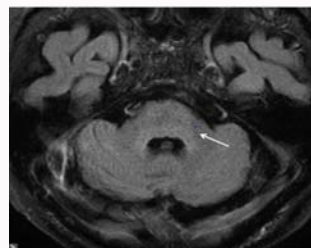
Subtotal regression of the hyper intense, non-enhancing tumor in the pons with regression of the mass effect and beginning atrophy in FLAIR images (white arrow).
